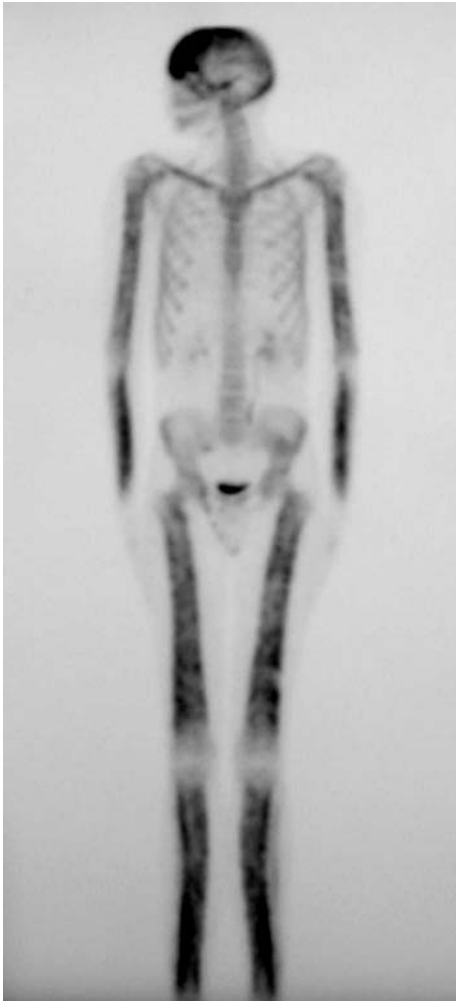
Whole body bone scintigraphy of a patient from family 13 showing the symmetrical distribution of the disease. Increased tracer uptake is visible in the diaphyseal portion of the long bones of the femora, lower legs, humeri and forearms, clavicles, and frontal bones. There is minor increased uptake at the parietal and occipital bones. Also note the slight valgus deformity of the knees.
